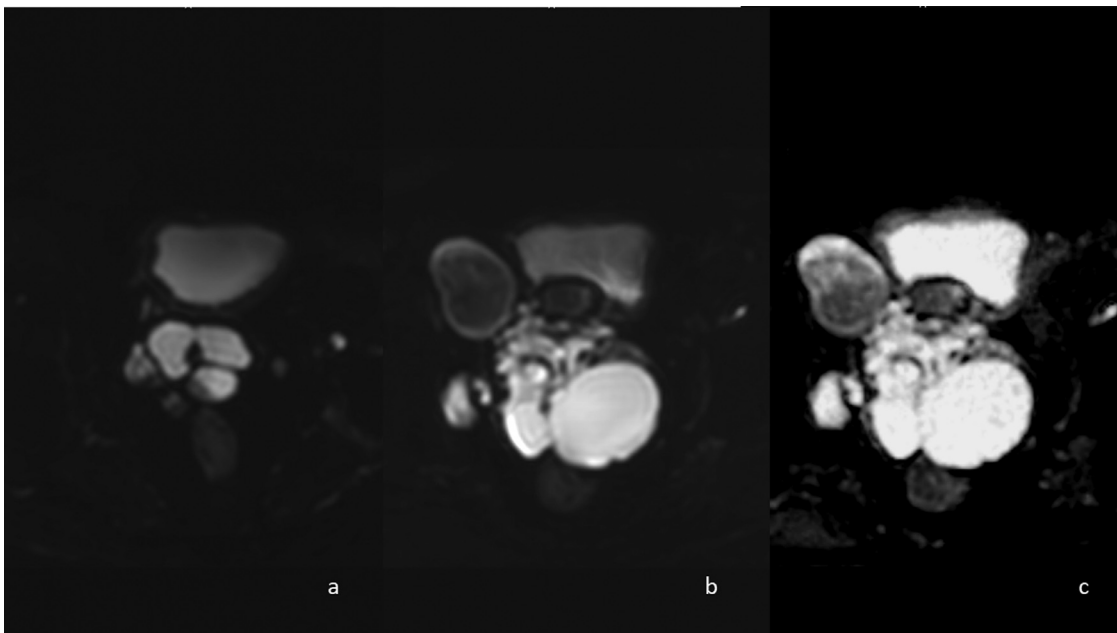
Diffusion-weighted (DW) magnetic resonance imaging with various gradient strength (b-value). (A) $b = 0$. (B) $b = 100$. (C) Apparent Diffusion Co-efficient (ADC) image with no reduced signal appearing on high b value (1000 s/mm^2).
